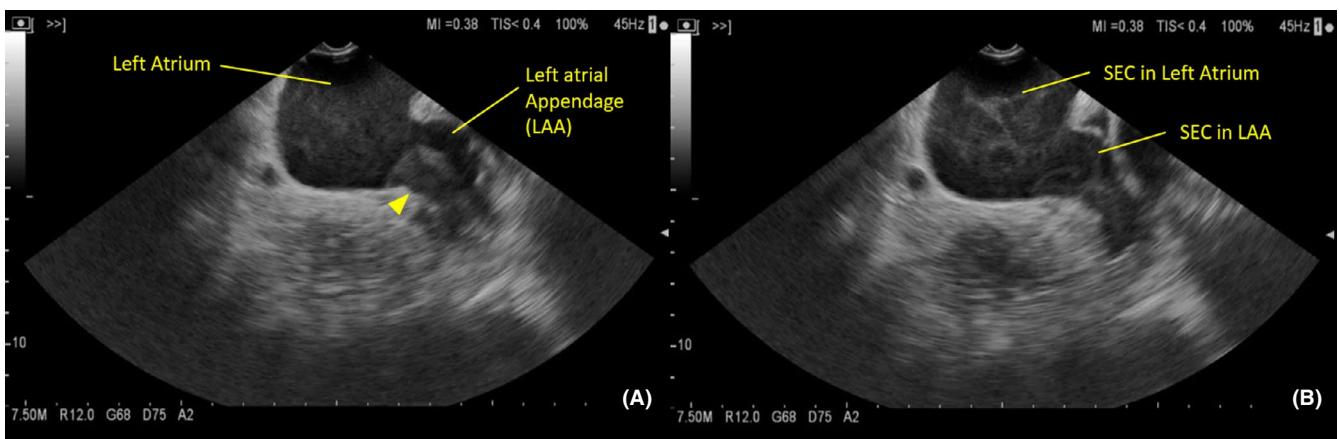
Transesophageal observations of the left atrium and the left atrial appendage (LAA) obtained via linear endoscopic ultrasound (L-EUS). A, L-EUS revealed an LAA thrombus (arrowhead). B, L-EUS showed spontaneous echo contrast (SEC; an echogenic swirling pattern of blood flow) in both the left atrium and the LAA
